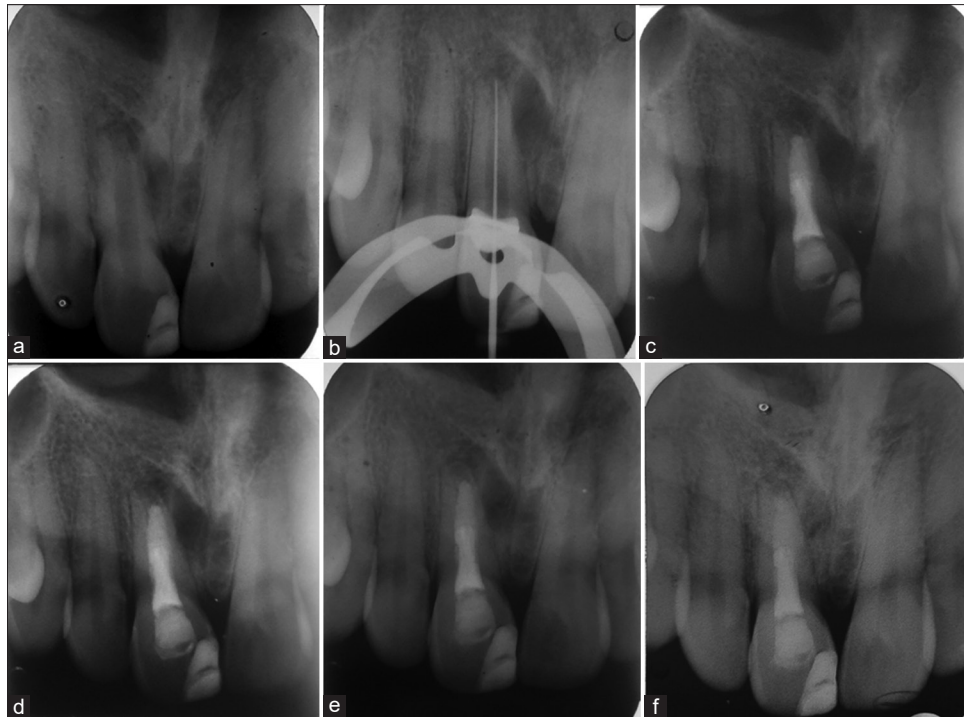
(a) A preoperative periapical radiograph of tooth #8. The tooth has an open apex and a periapical lesion and was diagnosed with necrotic pulp and asymptomatic apical periodontitis (b) working length estimation. (c) A periapical radiograph after biodentine placement, obturation and final restoration. (d) A periapical radiograph after 6-month follow-up. (e) A periapical radiograph after 18 month follow up period showing evidence of apical closure. (f) A periapical radiograph after 30-month follow-up period, showing complete resolution of periapical lesion and apical closure
